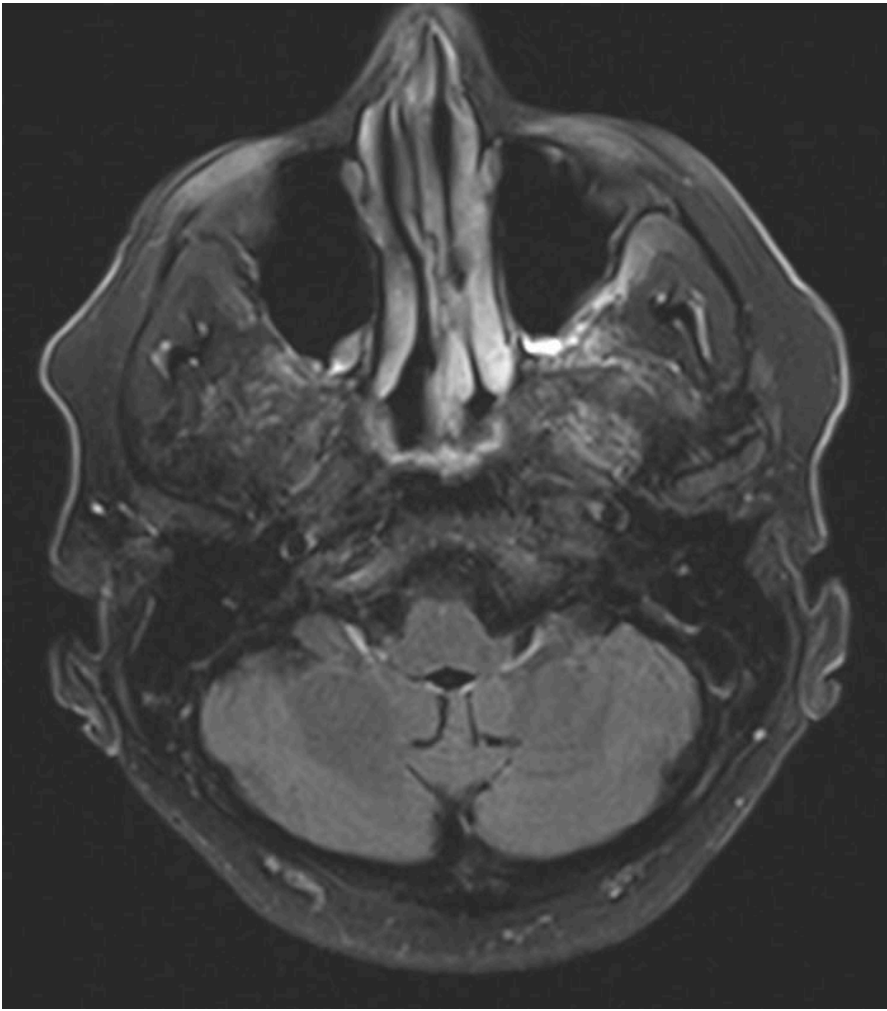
Increased T2-FLAIR MRI signal involving the periaqueductal gray and dentate nucleus.
